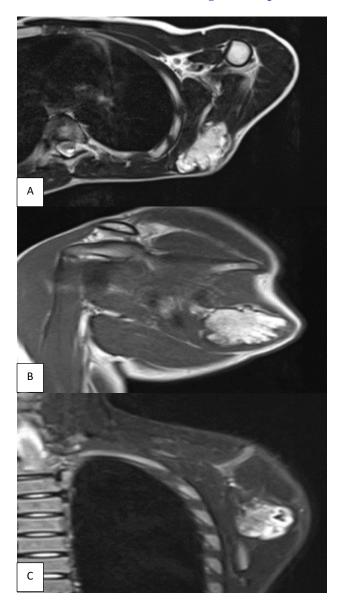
(A-C): MRI T2W axial, MRI T1W sagittal and MRI T2W coronal.
